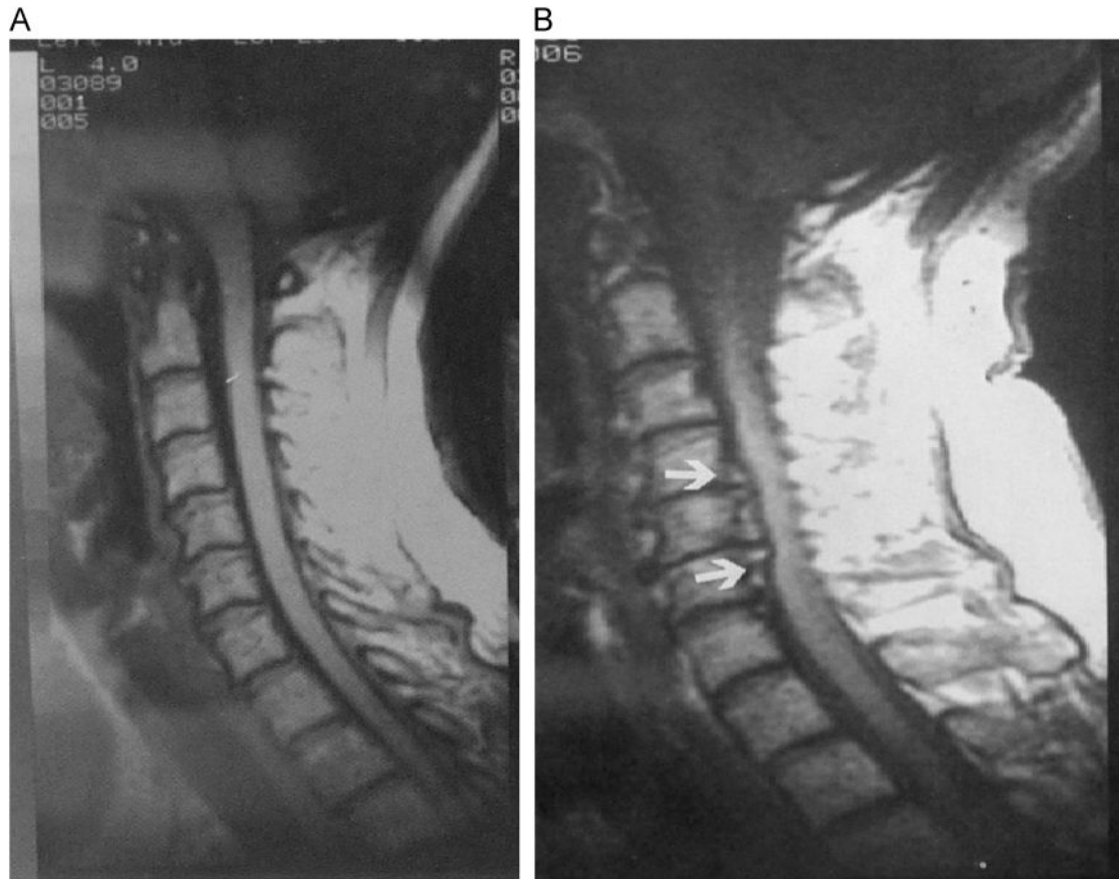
(A) Normal cervical magnetic resonance imaging (MRI). (B) MRI of cervical spinal stenosis (arrows).
